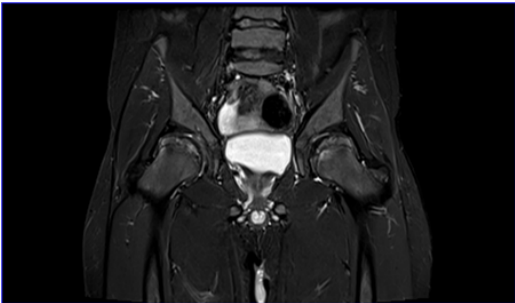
STIR coronal MRI of a female child showing sclerosis and deformity of bilateral femoral head-Perthes disease.
